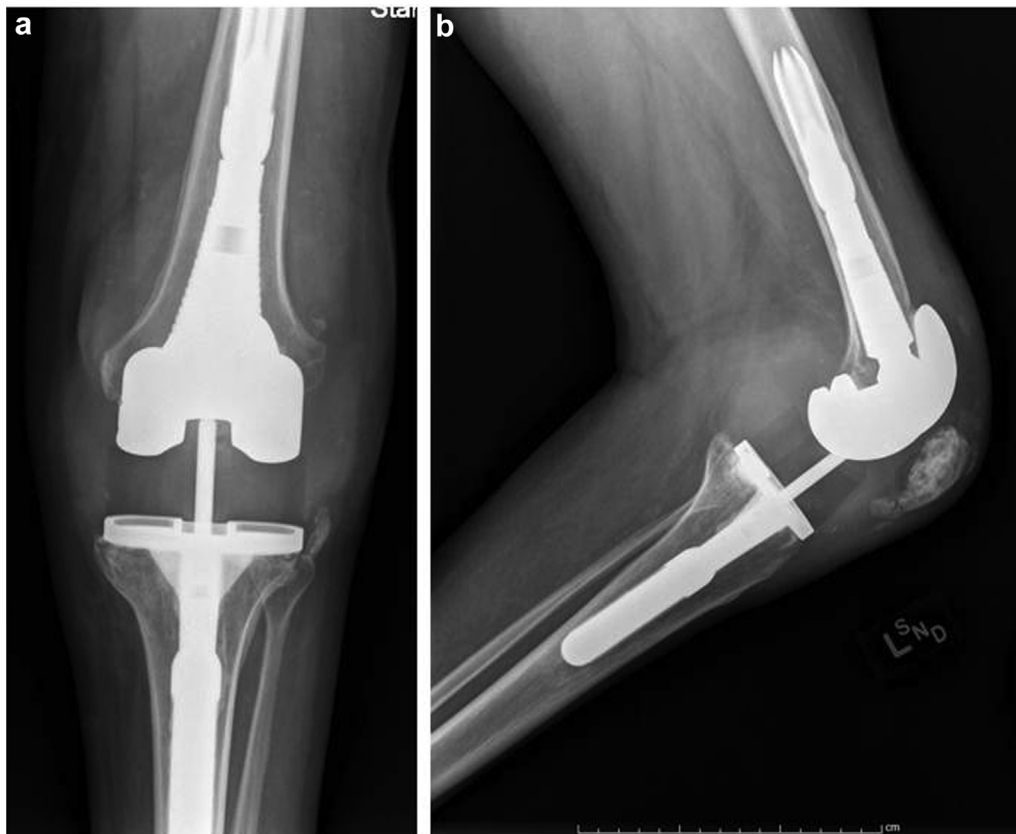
Preoperative anteroposterior (AP) (a) and lateral (b) radiographs demonstrating well-fixed implants with good bonding to the porous-coated femoral metaphyseal sleeve.
